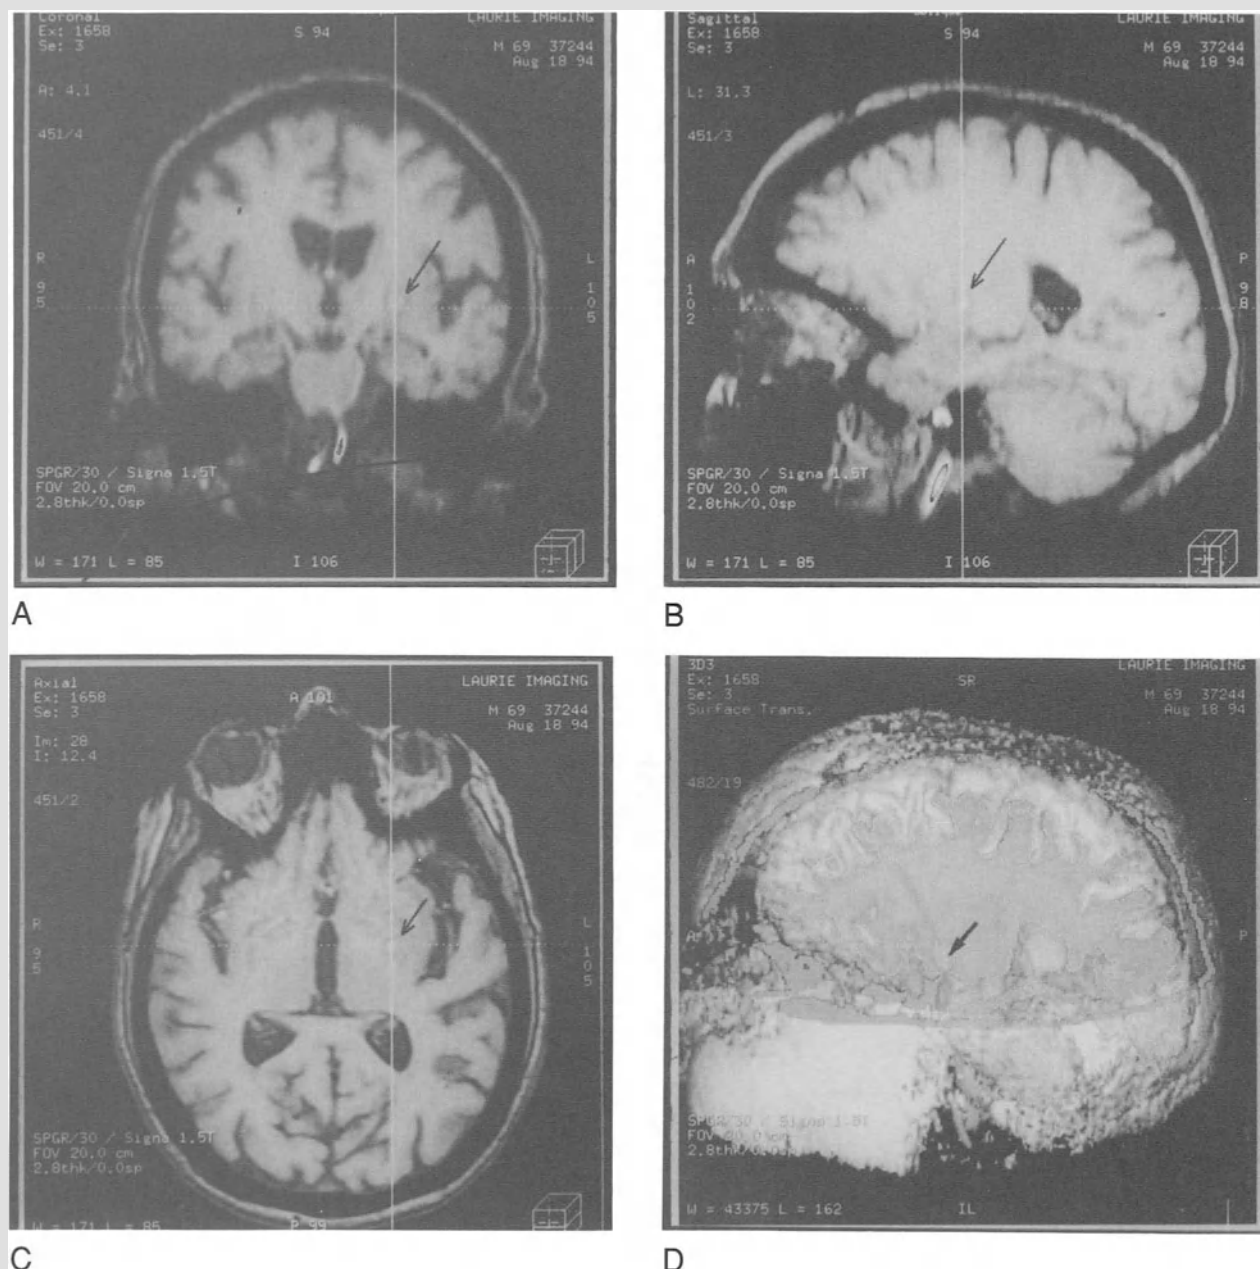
(A–D) Post-operative MR images in multiplanar 2D and 3D volume surface rendered views. (Arrows: epicenter of lesion)
